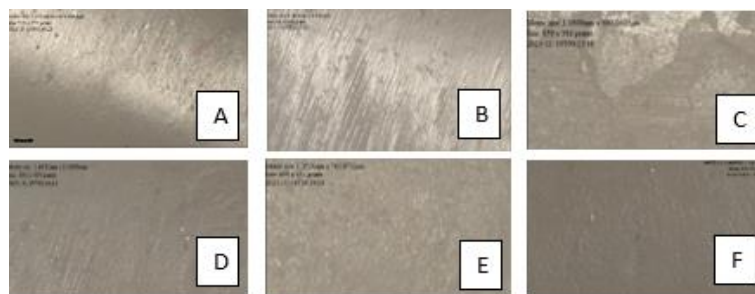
Surface Profilometric Images Of Group 2 – GC Gold Label Hybrid : A- After Initial Finishing And Polishing, B – After Thermocycling, C – After Manual Instrumentation, D – After Ultrasonic Instrumentation, E – Post Prophylactic Polishing (Manual Instrumentation Group) And F - Post Prophylactic Polishing (Ultrasonic Instrumentation Group)
